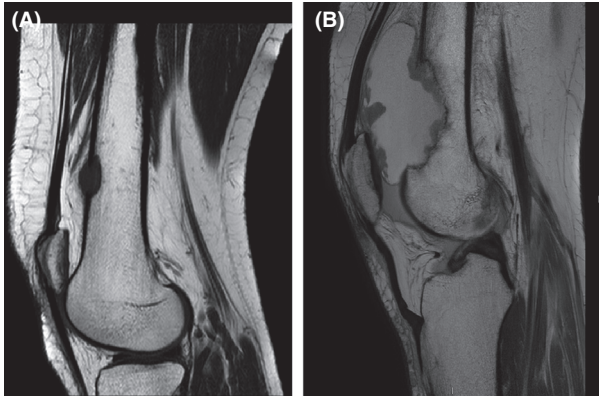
(A) T1 sagittal MRI of the right femur. (B) T1 sagittal MRI of the left femur.
